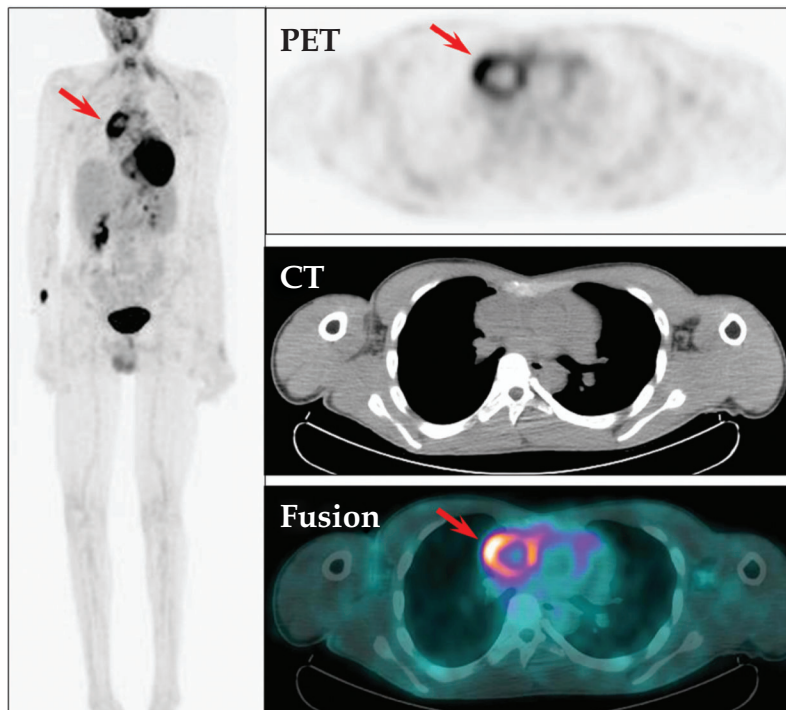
FDG PET-CT images of a patient with superior vena cava thrombosis. Intense FDG activity is seen at the periphery of the thrombus as pointed by arrows. Associated dilation of the superior vena cava in this region is also apparent on CT.
